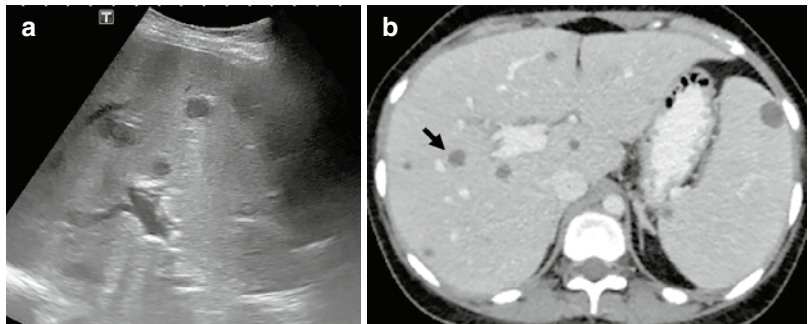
Candida* infection of the liver. Ultrasound shows multiple well-defined, hypoechoic lesions in a 19-year-old lady with acute leukemia and sepsis from *Candida* (a). CT images show discrete low attenuation lesions (b). *Candida* was confirmed on liver biopsy
